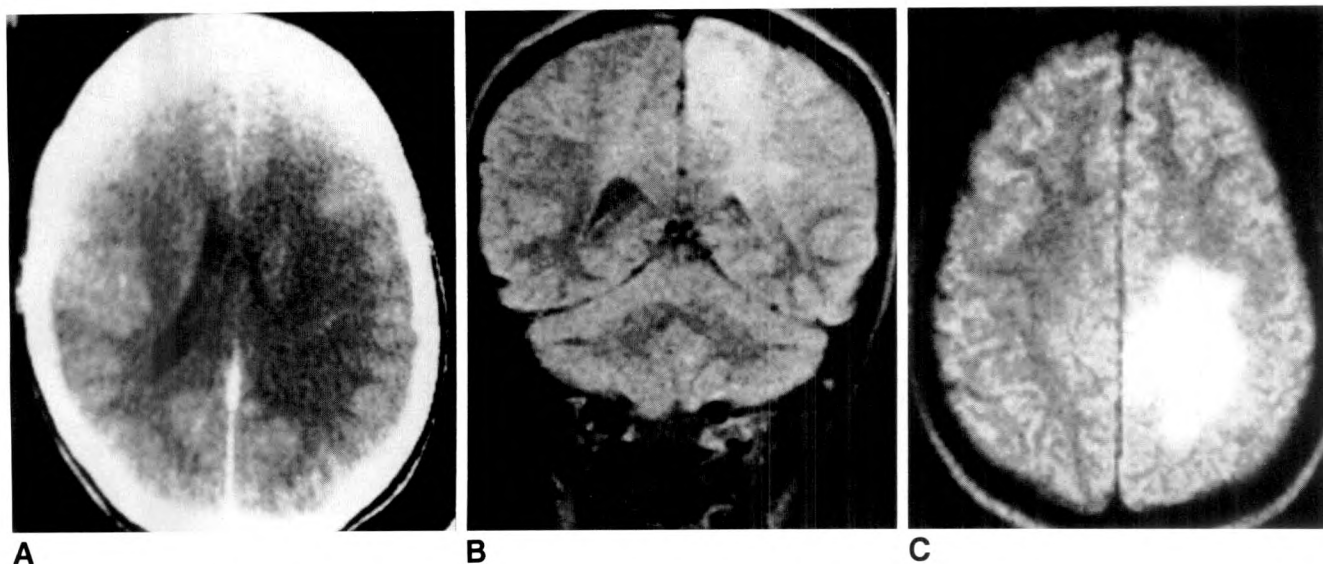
A, CT shows poorly defined area of low attenuation. Whether tumor crosses midline is uncertain.
